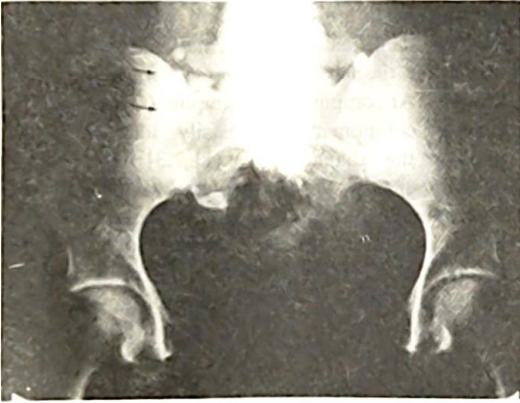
(Case 5): Plain film of pelvis showing a right lateral curvilinear shell of bone (arrow) and with teeth overlying the sacrum.
